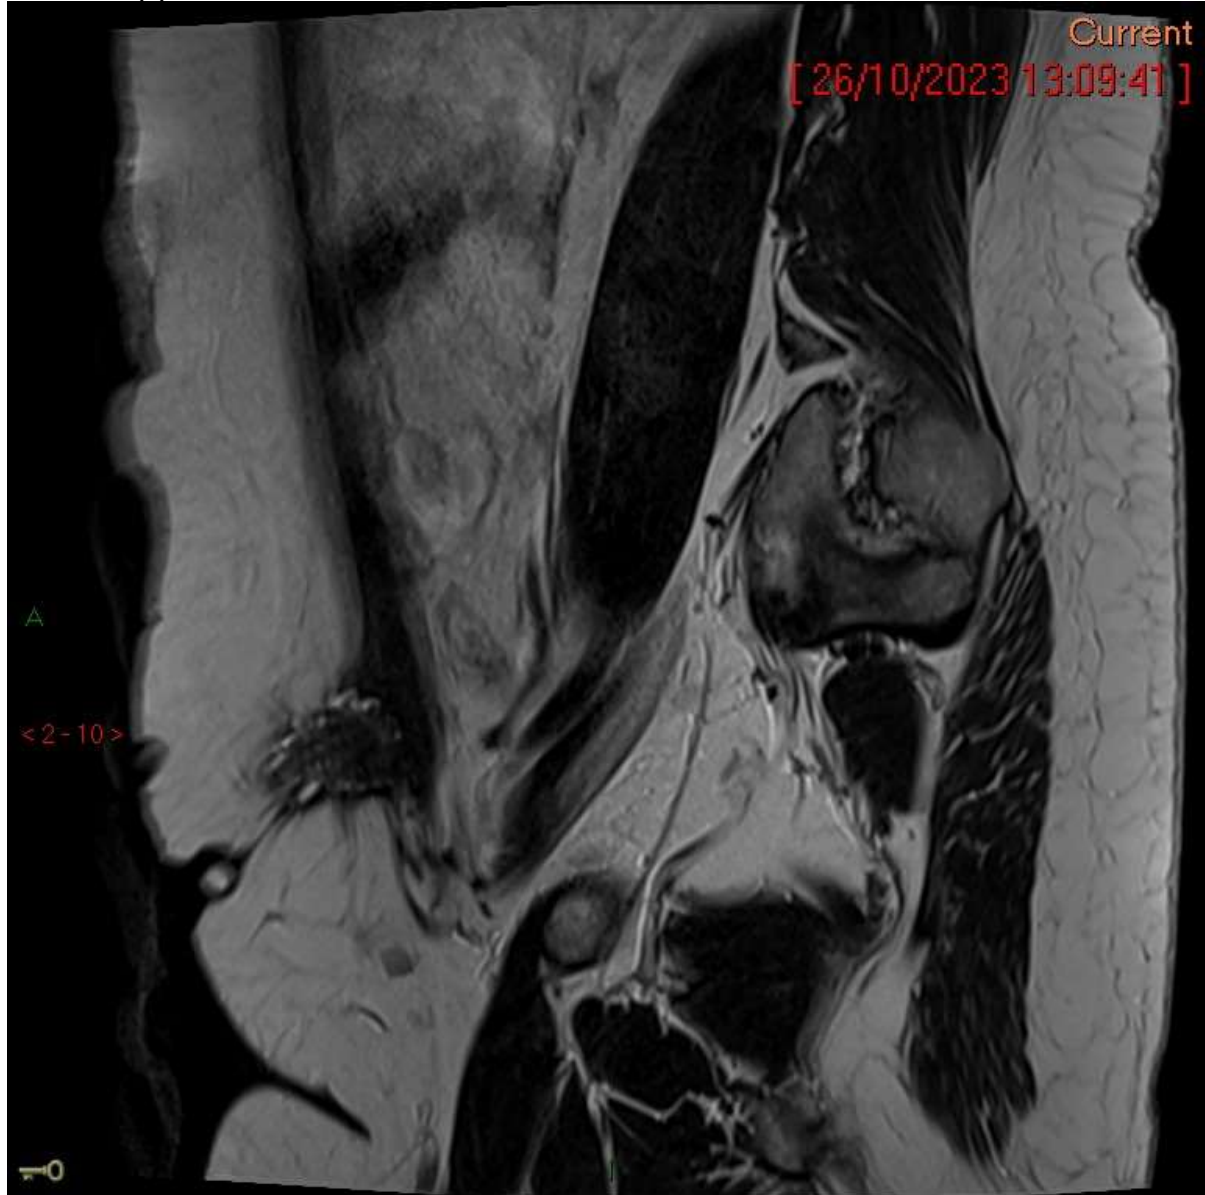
Single sagittal T2-weighted sequence
